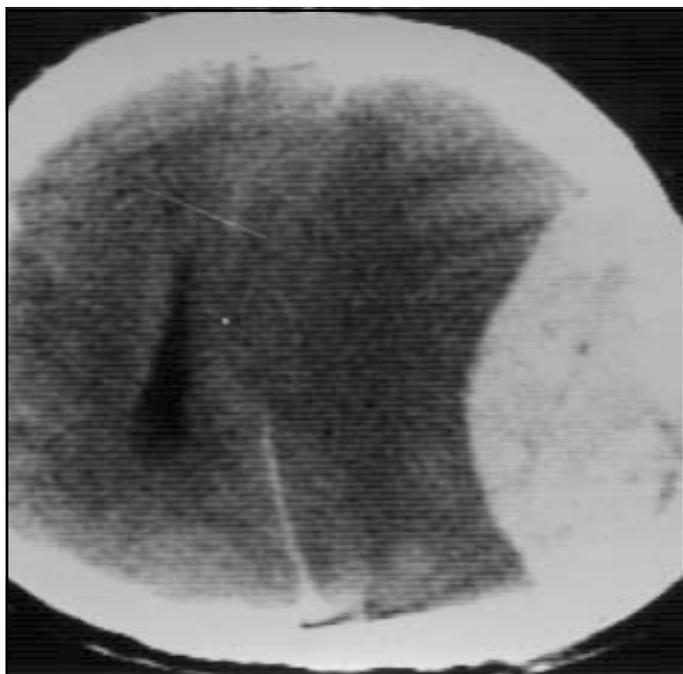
CT scan of a patient with an acute extradural haematoma
